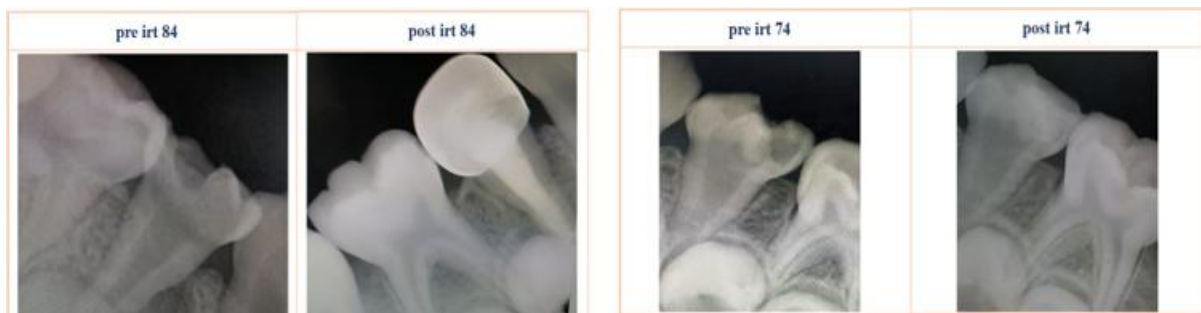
Intraoral periapical radiographs irt 74,84
